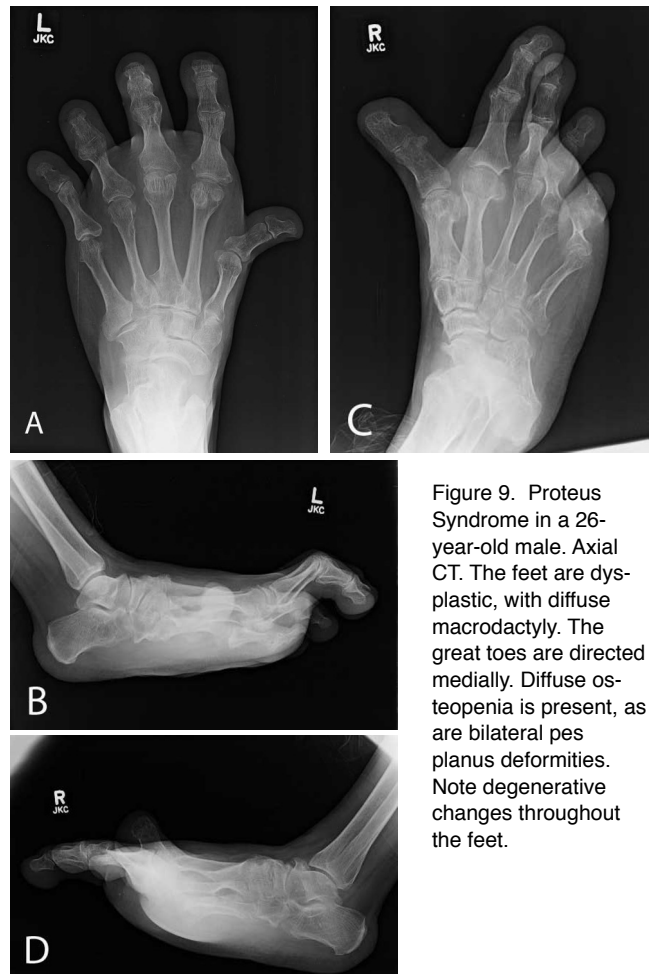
Proteus Syndrome in a 26-year-old male. Axial CT. The feet are dysplastic, with diffuse macrodactyly. The great toes are directed medially. Diffuse osteopenia is present, as are bilateral pes planus deformities. Note degenerative changes throughout the feet.
